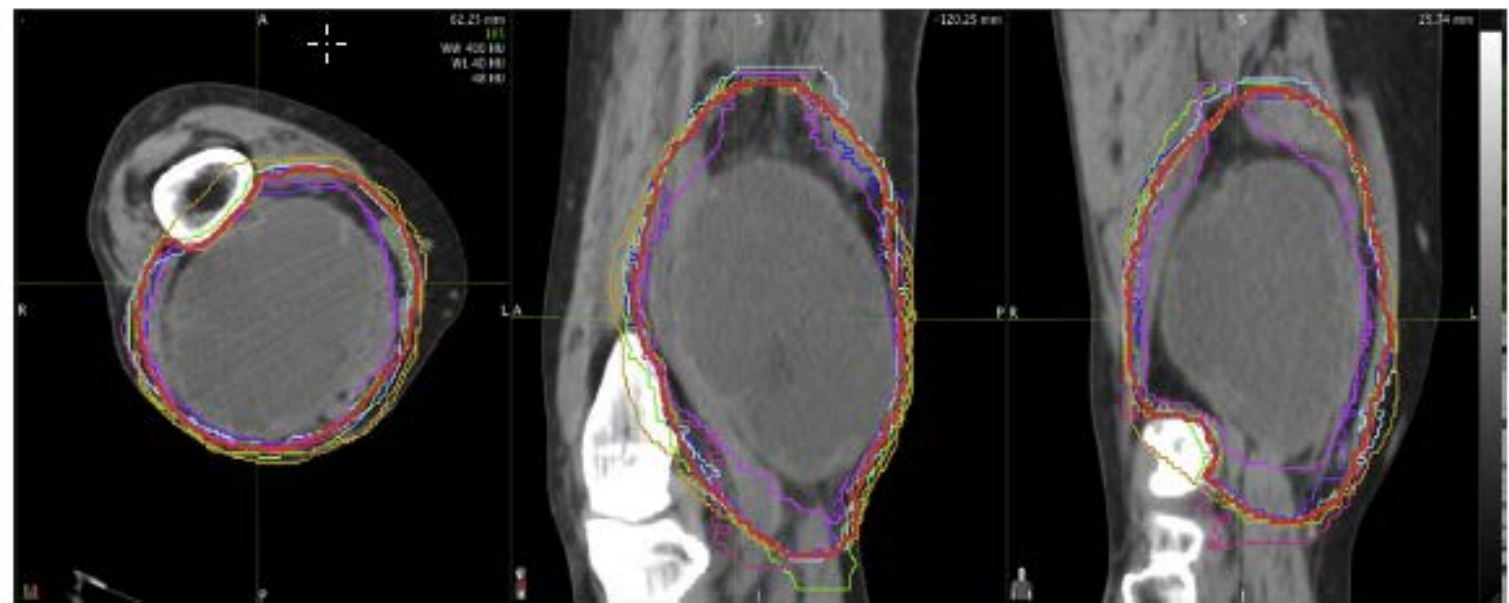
Example of individual and consensus (red) contours of clinical target volume on axial computed tomography for patient with large high-grade sarcoma of distal aspect of right thigh.
